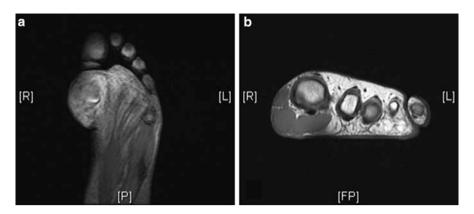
Coronal (a) and axial (b) T1-weighted MRI images of a left foot low grade myoepithelioma involving flexor hallucis longus and subcutaneous tissue
